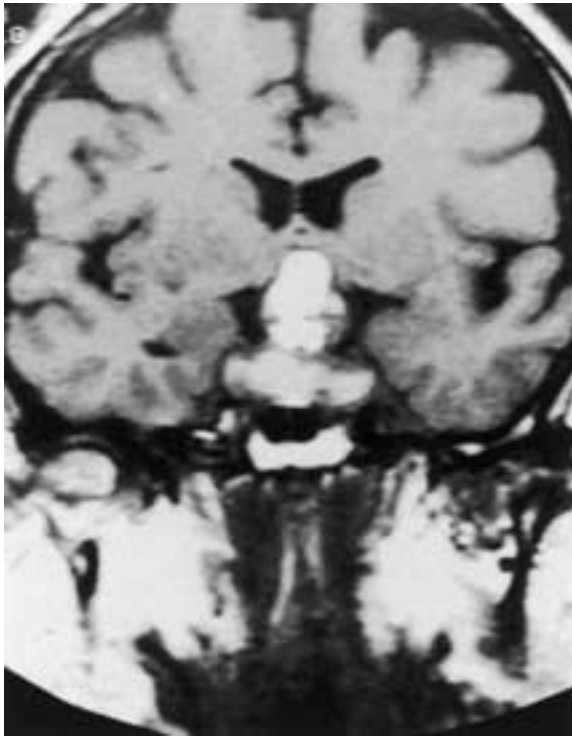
Pituitary adenoma with intratumoral hemorrhage. Coronal T1-weighted image shows an intrasellar and suprasellar mass of mixed signal intensity, which is caused by the presence of methemoglobin. Note that the mass extends laterally and compresses both cavernous sinus regions.
